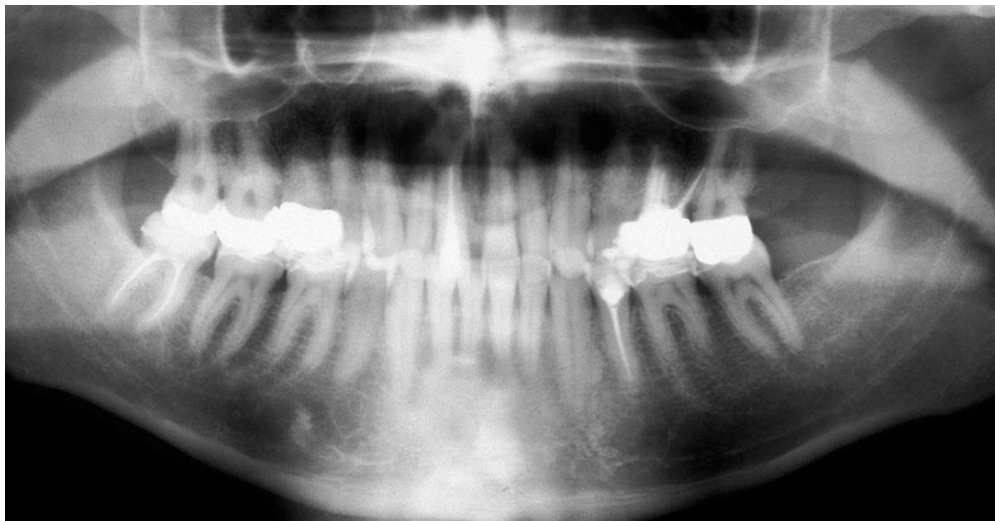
(C) Orthopantomogram demonstrates multiple posterior restorations, including a number of endodontic treatments, especially also for tooth #8.
